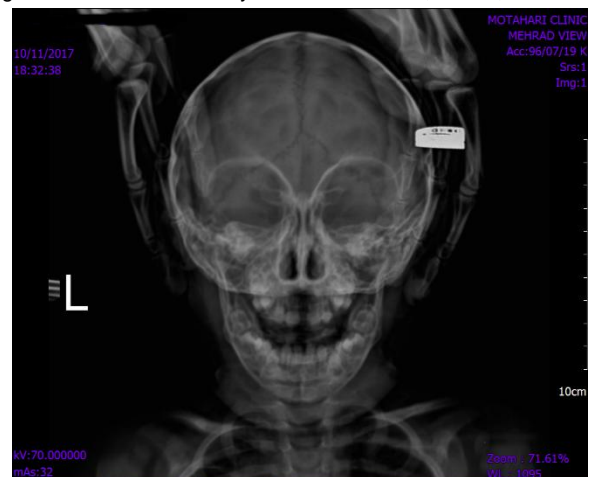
Pre-intervention X-ray Motahari Clinical, Shiraz, Iran
